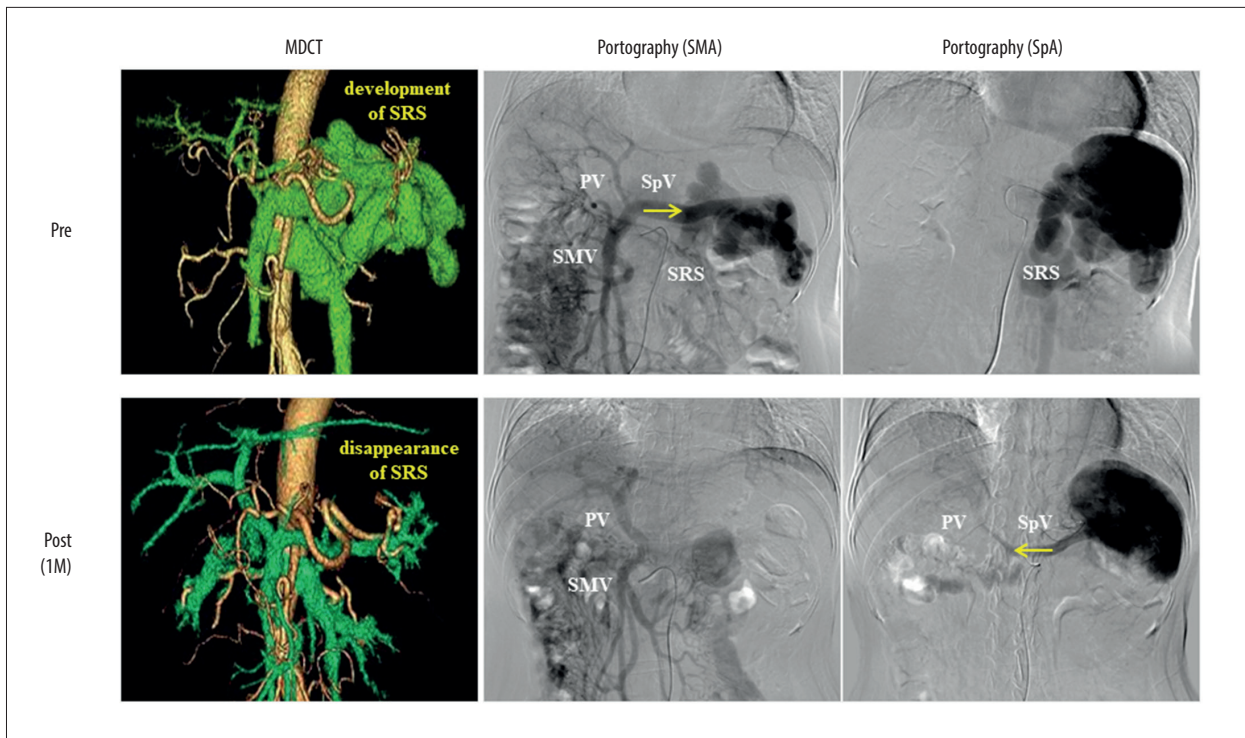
MDCT and indirect portography images obtained through the SMA and SpA before and 1 month after BRTO. MDCT images obtained before (upper left panel) and after (lower left panel) BRTO demonstrated that the procedure caused the complete disappearance of the SRS. Indirect portography through the SMA during the venous phase of superior mesenteric angiography before BRTO depicted contrast medium in the SMV and PV, which drained hepatofugally toward the SRS via the SpV (upper middle panel). Indirect portography through the SMA after BRTO revealed that the SMV flow entered the liver via the PV; consequently, the SpV and SRS were not visible (lower middle panel). Indirect portography through the SpA during the venous phase of splenic angiography before BRTO depicted contrast medium in the SpV of the splenic hilum, which communicated with the left renal vein via the SRS (upper right panel). Indirect portography through the SpA after BRTO demonstrated that all venous blood in the SpV flowed hepatopetally into the PV; consequently, the SRS was not visible (lower right panel). The arrows indicate the direction of the splenic venous flow. MDCT – multi-detector row computed tomography; SMA – superior mesenteric artery; SpA – splenic artery; SRS – splenorenal shunt; PV – portal vein; SMV – superior mesenteric vein; SpV, splenic vein; 1 M – 1 month.
